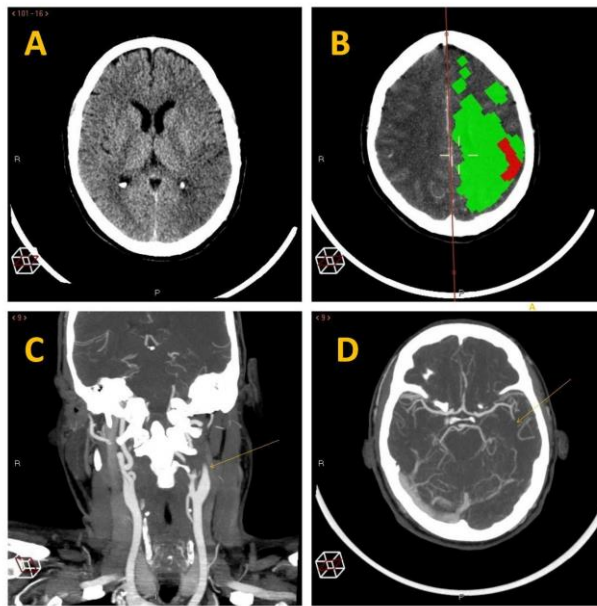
A) Unenhanced brain CT shows a hypoattenuated area in the left middle cerebral artery territory, meaning acute ischemia B) Perfusion mismatch with 90% hypoperfused affected tissue (green) C) CT angiography shows flame-shaped occlusion of the proximal left internal carotid artery compatible with dissection of this vessel (arrow). D) Occlusion of the left M2 segment (arrow).
